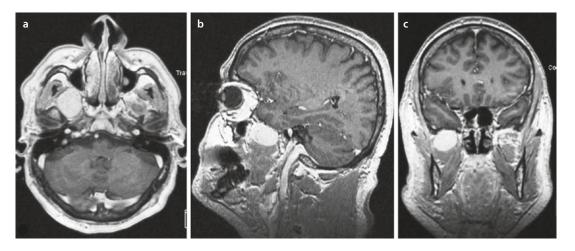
MRI with contrast in the axial a, sagittal b, and coronal plane c shows a tumour mass with contrast enhancement in the right pterygopalatine fossa that was
